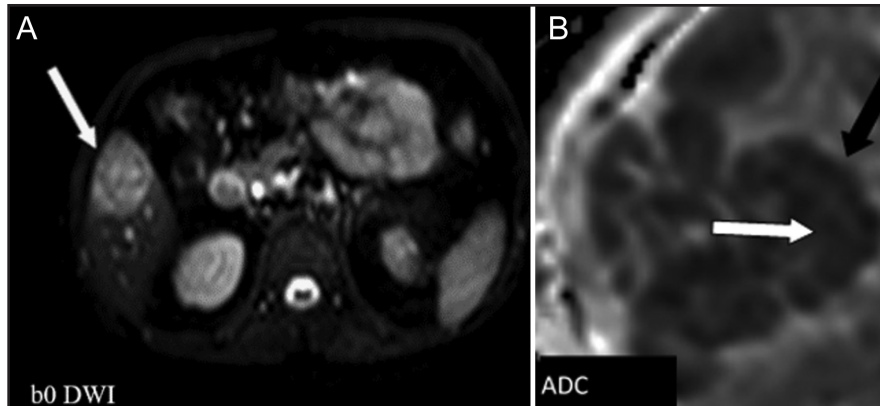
The abscess capsule is hypointense and the center is hyperintense on DWI. In the ADC map, the abscess capsule has a high value and the center has a low value. ADC, apparent diffusion coefficient; DWI, diffusion-weighted imaging.
